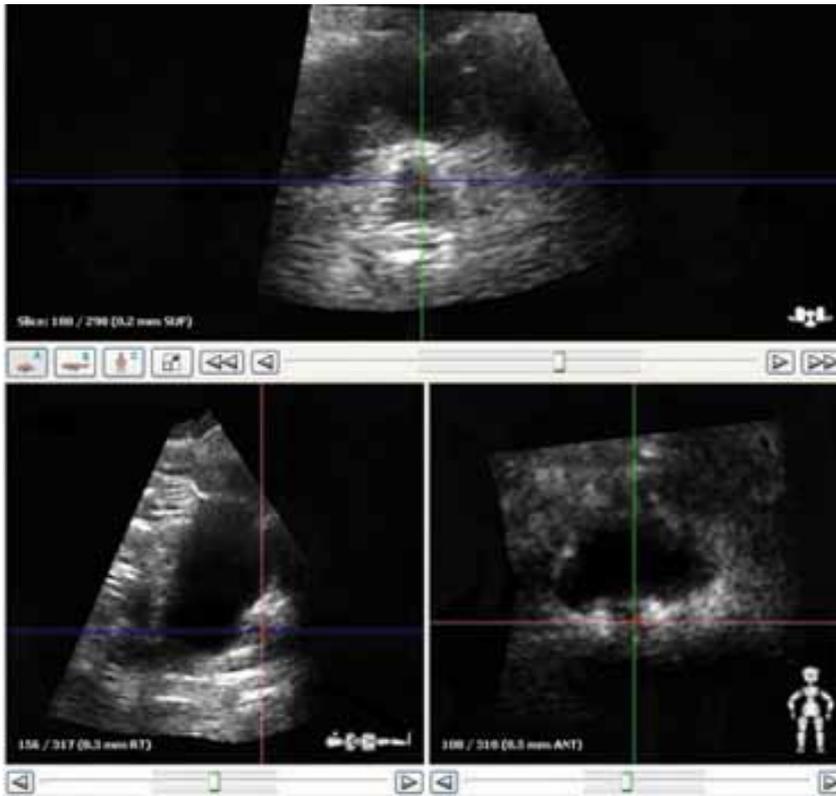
Axial, sagittal, and coronal view of 3D ultrasound imaging.
